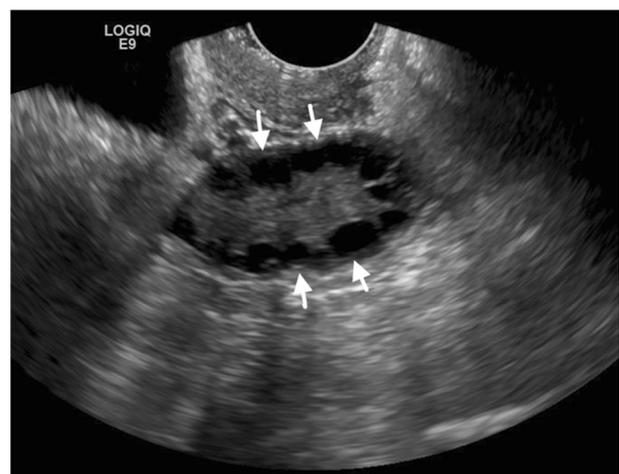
Longitudinal grayscale image from a transvaginal pelvic ultrasound demonstrates multiple small peripherally arranged follicles (arrows) giving the characteristic “string-of-pearls” appearance in this patient with clinically proven PCOS
